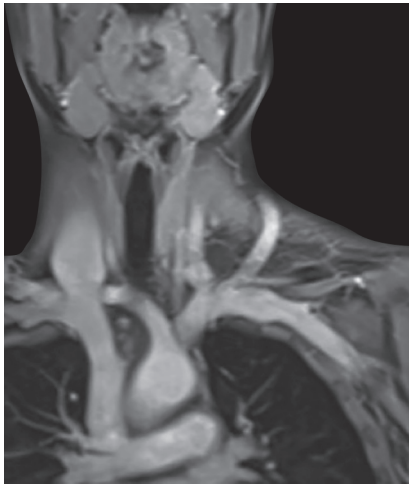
MRI scan showed swelling at the insertion of the thoracic duct
